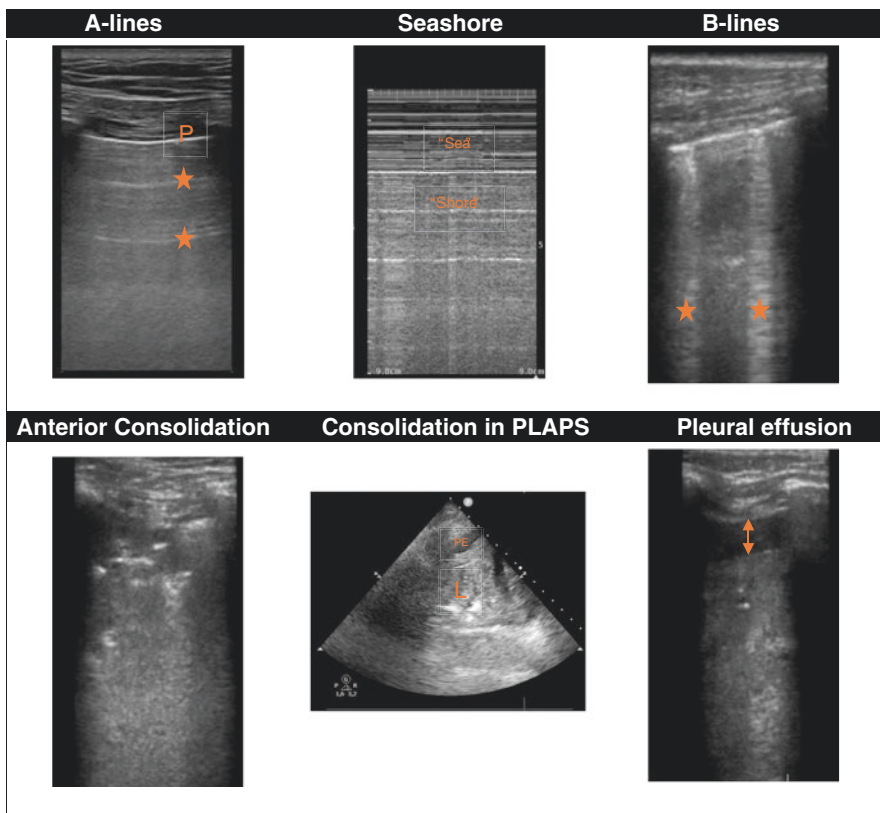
Artefacts and signs observed during lung ultrasound. *P* Pleura, *PE* pleural effusion, *L* lung, *Star* B-line, *Arrow* pleural effusion
